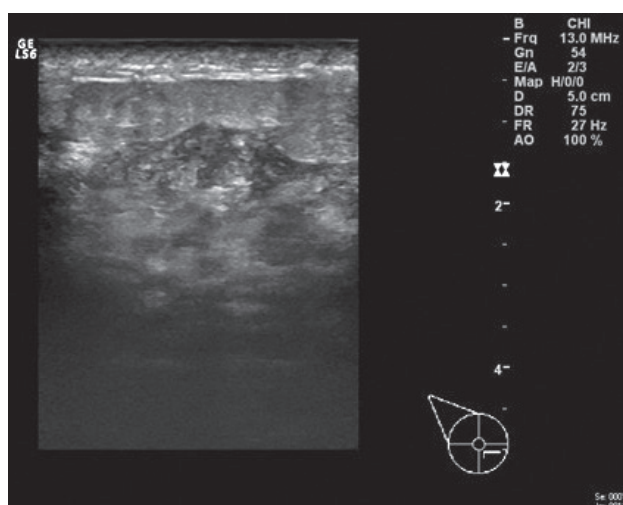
Ultrasonography of the patient's right breast lesion. Focal inflammation with moderate skin thickening in the lower inner quadrant.
